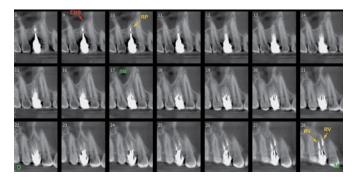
CBCT endodontic treatment follow-up (Dec/2015). Endodontic material can be seen inside the root canals of tooth #14, indicative of end-odontic therapy and presence of intra-canal pins.
